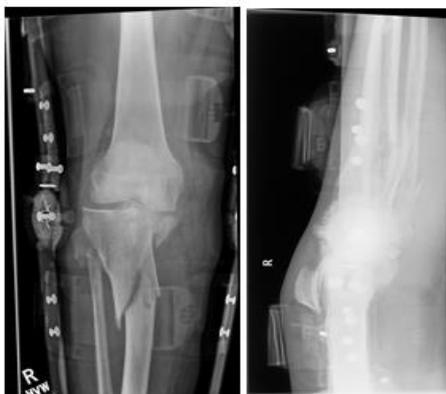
Radiographs on the day of the injury for Patient 1
